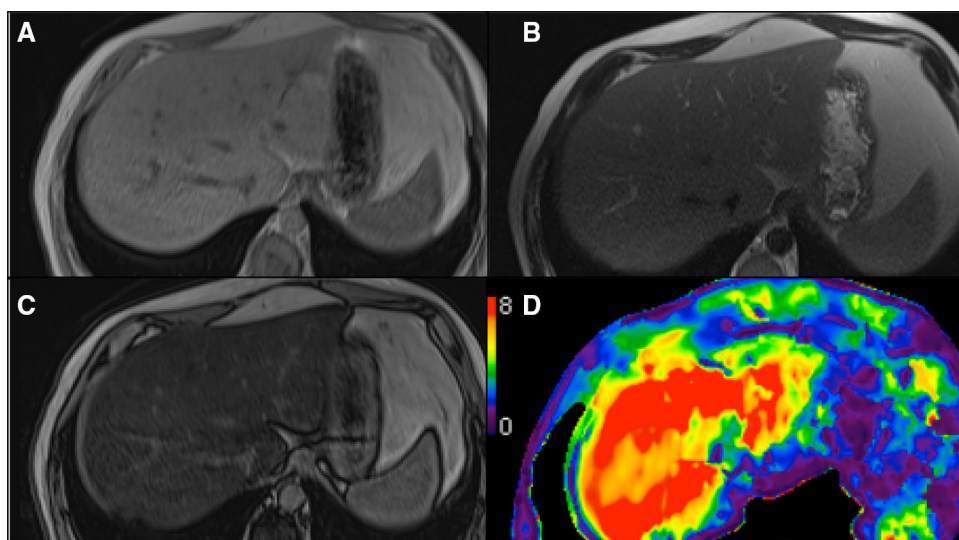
A–D A 57-year-old man with fatty liver disease. Hepatic steatosis is seen with signal loss on the opposed phase imaging relative to the in phase images (A and C), but with normal liver morphology on T1- and T2-weighted imaging (A–C). (D) MR elastography shows unsuspected cirrhosis (stiffness 7.5 kPa), making biopsy unnecessary.
